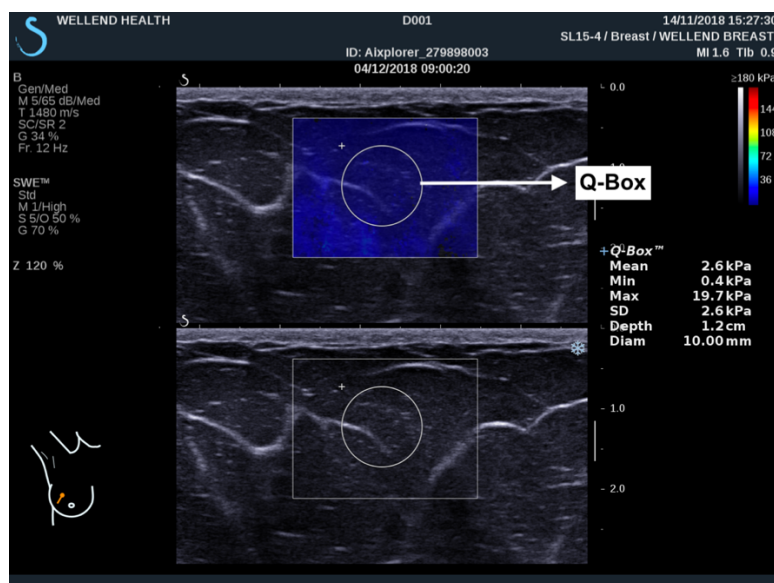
The Q-Box™ displayed on both the SWE mode and the B-mode ultrasound output
